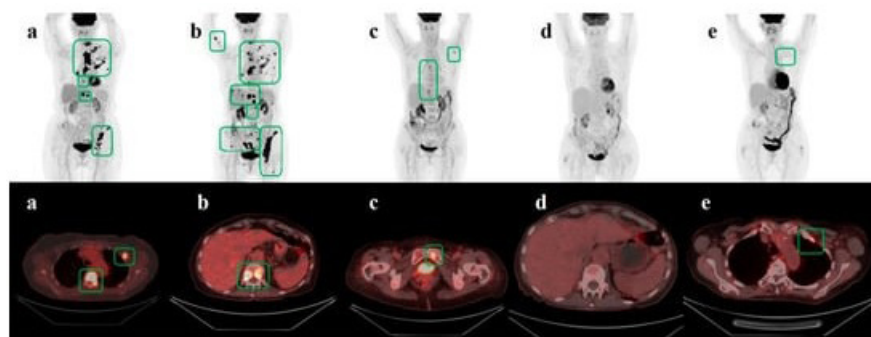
The figure shows serial FDG-PET/CT images (a–e) for a patient with primary treatment for ductal carcinoma in situ in 2011; Van Nuys, gr. III. No adjuvant chemotherapy or radiotherapy was given after surgery. Baseline FDG-PET/CT in February 2017 (a) showed metastases in bone and lymph nodes. She was treated with thoracic radiotherapy and a first series of TDM1. Follow-up scan in April (b) showed progressive metabolic disease possibly due to delayed initiation of treatment. The patient received five more series of TDM1. A third scan in May 2017 (c) showed partial metabolic regression before the patient received the sixth and seventh series of TDM1. The scan from July 2017 (d) showed complete metabolic regression. Treatment was stopped thereafter due to side-effects. The control scan in February 2018 (e) showed a tiny bone lesion suspicious of relapse. TDM1 = Trastuzumab Emtansine. Green squares outline metastatic lesions.
